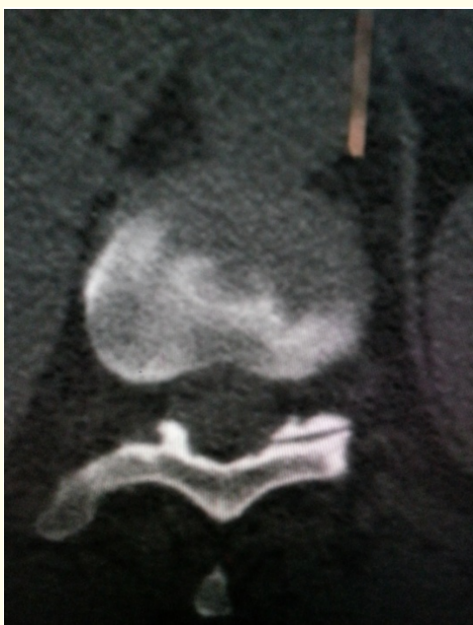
Axial CT image demonstrating beak like ossification of right ligamentum flavum.
